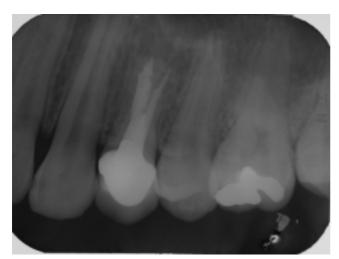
One-year postoperative radiograph confirming healing of the periapical region.
